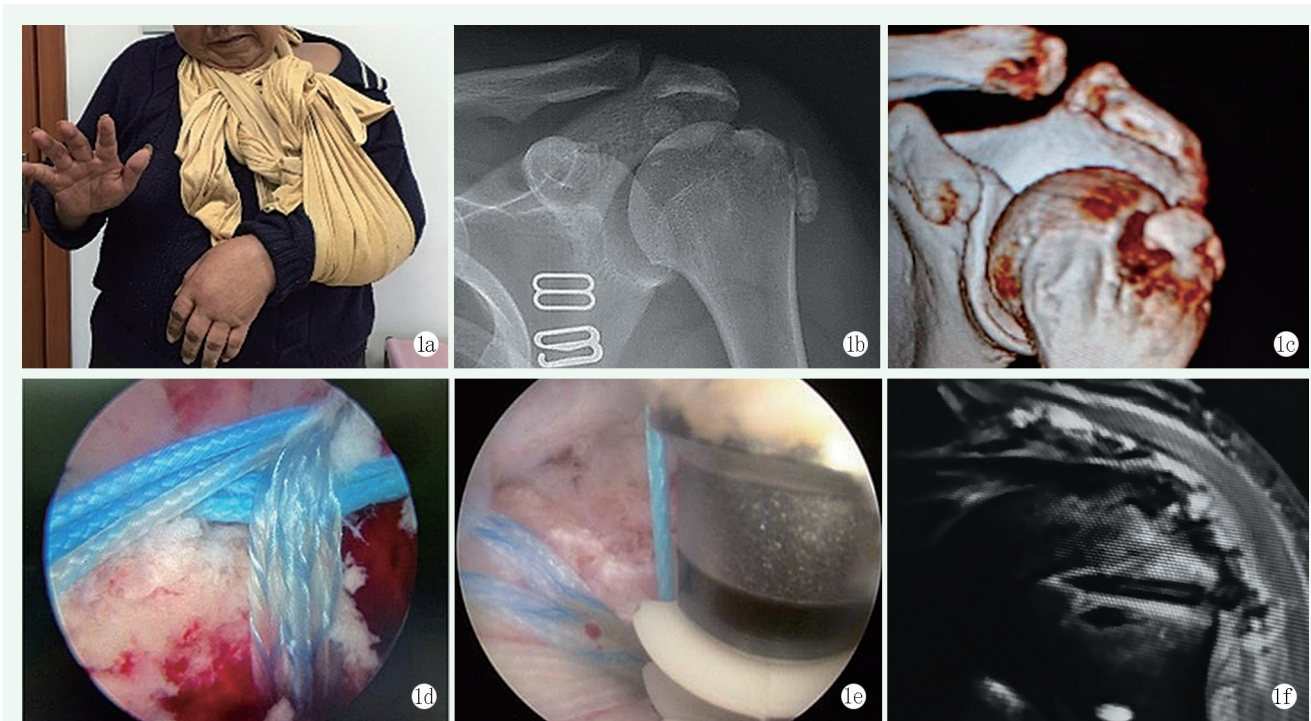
患者，女，79 岁 1a: 左腕关节下垂、手背肿胀、伸拇、伸指、伸腕功能障碍 1b, 1c: 初次复位后、术前 X 线片和 CT 扫描三维重建显示肩关节已复位，肱骨大结节骨折仍有移位 1d, 1e: 双排缝线桥技术固定骨折块和肩袖，缝线呈网状固定冈上肌腱 1f: 术后 MRI 显示肱骨大结节骨折复位，骨折与冈上肌腱固定良好
